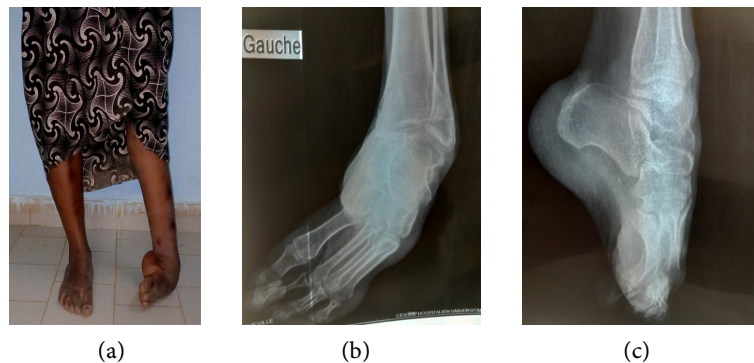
Inveterate paralytic varus equinus foot before surgery: ((a): front view; (b): front radiograph; (c): profile radiograph).
